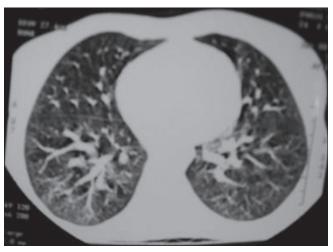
High-resolution computed tomography chest of case of rheumatoid arthritis showing thickening of central interstitium and intralobular septae resulting in reticular pattern of both lungs
